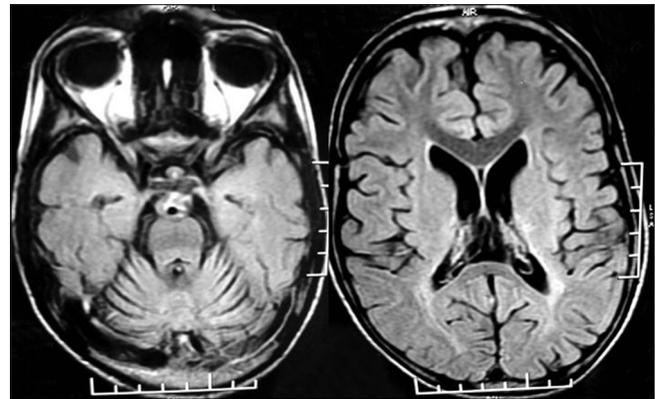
Magnetic resonance imaging of cranium revealed cerebellar atrophy out of proportion to the cerebral atrophy (Axial T2 Fluid attenuated inversion recovery sequence)
